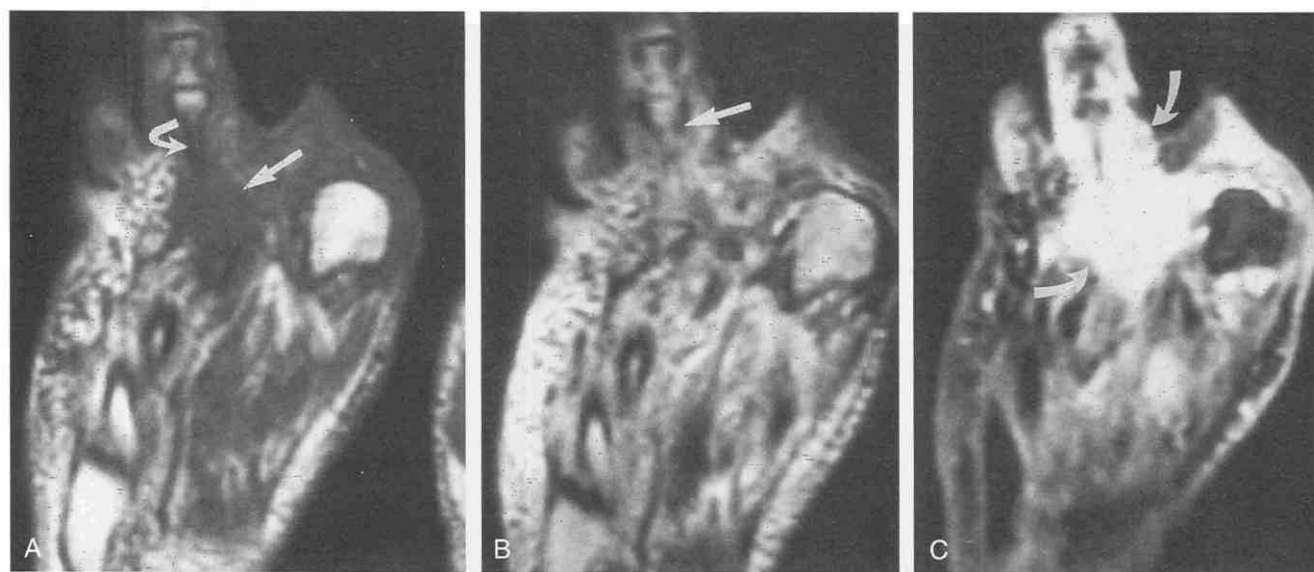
On a T1-weighted image (A), low signal intensity is seen within the marrow of the second ray (*curved arrow*). Adjacent soft tissue mass edema is seen (*straight arrow*). The marrow increases in intensity on T2-weighted (fast spin-echo) images (B) (*arrow*) and enhances after gadolinium administration (C); this is consistent with osteomyelitis. Extensive soft tissue enhancement is also seen (*arrows*).
